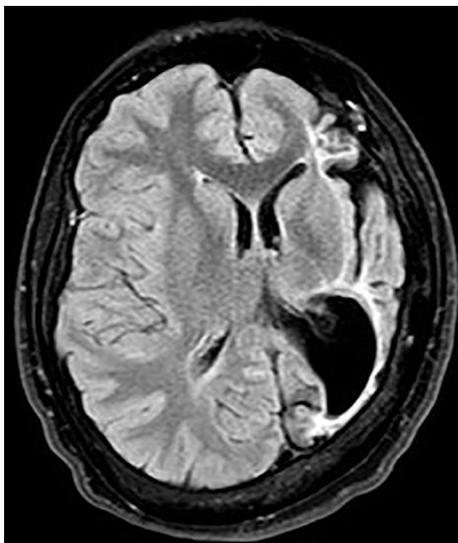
A 22-year-old patient with left cerebral hemiatrophy, ipsilateral atrophy of the basal ganglia (MRI Flair).
